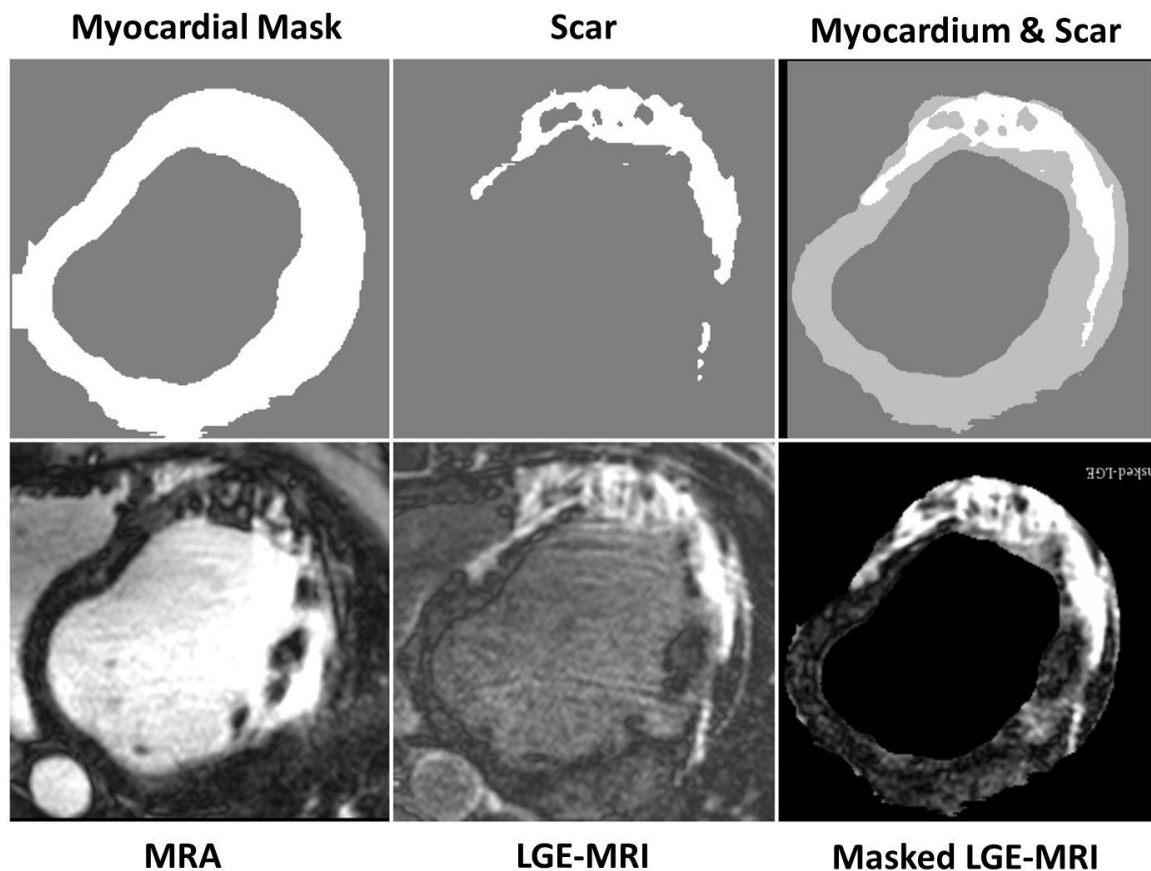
At the top, the manual segmentation of the myocardium (left), manual scar segmentation (middle) and the scar aligned within the myocardium region. At the bottom, there is MRA (left), LGE-MRI (middle), and the masked LGE-MRI (right). The masked LGE-MRI is obtained using LGE and the manual myocardium by element-wise multiplying the LGE-MR images and the binary myocardium segmentations.
